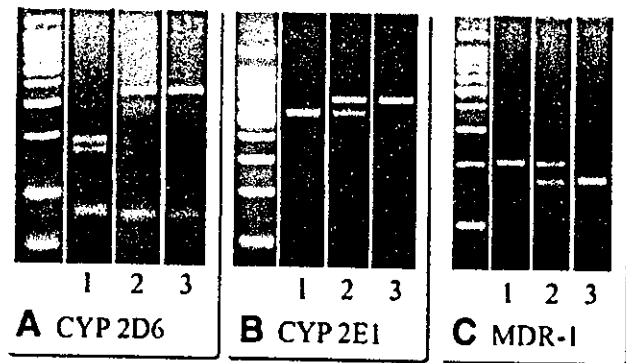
Restriction fragment length polymorphism analysis of (A) CYP2D6 G1934A, (B) CYP2E1 c1/c2, and (C) MDR1 C3435T SNPs. PCR products of CYP2D6, CYP2E1, and MDR1 were digested with restriction enzymes *Bst*NI, *Rsa*I, and *Sau*3AI, respectively, and resolved via agarose gel electrophoresis. Restriction fragment patterns were scored as: (A) non-CYP2D6*4 homozygotes (77, 161, and 183 bp) in lane 1, heterozygous in lane 2, or CYP2D6*4 homozygous (77 and 344 bp) in lane 3; (B) CYP2E1 wild-type homozygous c1/c1 (360 and 50 bp) in lane 1, heterozygous c1/c2 in lane 2, or mutant-type homozygous c2/c2 (410 bp) in lane 3; and (C) MDR1 homozygous TT (197 bp) in lane 1, heterozygous CT in lane 2, or homozygous CC (158 and 39 bp) in lane 3. CYP, cytochrome P450; MDR, multidrug resistance.
